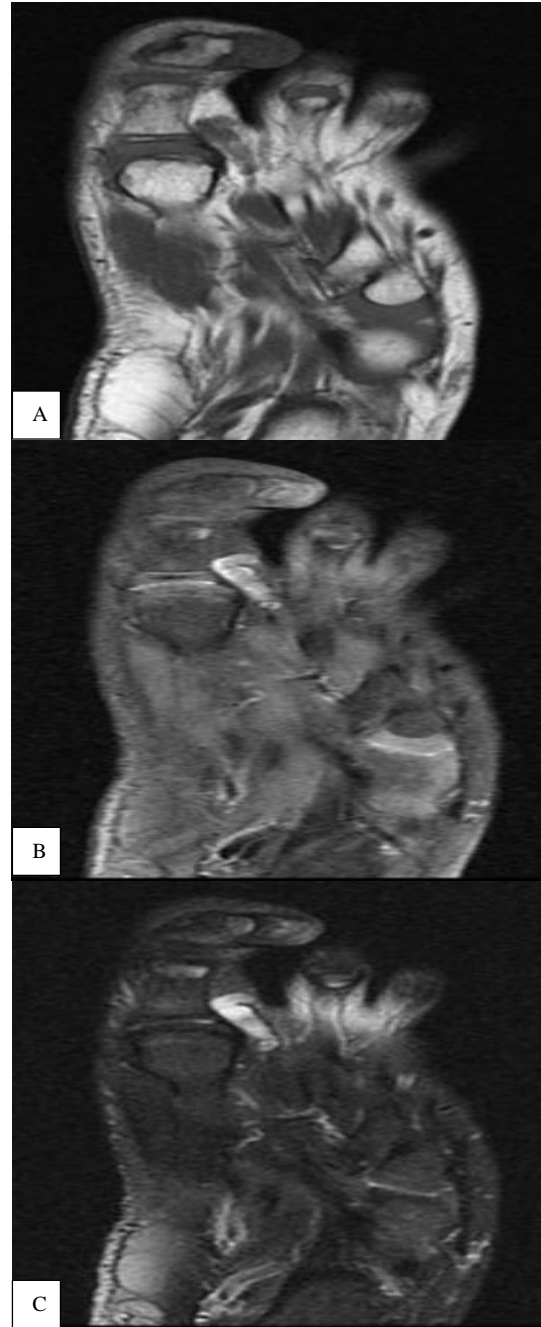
(A-C): MRI sequence images showing the nature of the tumor.
